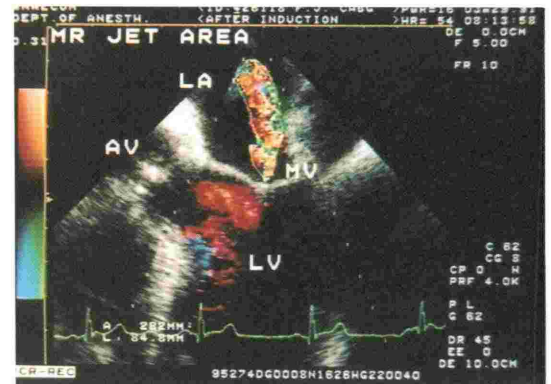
Transesophageal color Doppler imaging of mitral regurgitation. Mitral regurgitant jet area was traced with a track ball and calculated. LA: left atrium. MV: mitral valve. LV: left ventricle. AV: aortic valve.
